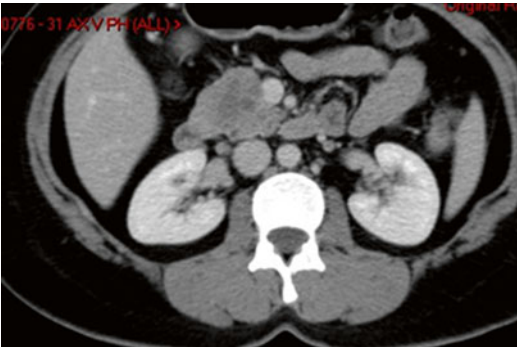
An abdominal CT demonstrated a hypodense solid mass in the head of the pancreas. The mass measured approximately 3.1 cm × 3.9 cm × 4.1 cm. It was a heterogeneous enhancing mass. No vessel invasion was observed. No peri-lesional lymph node was observed
